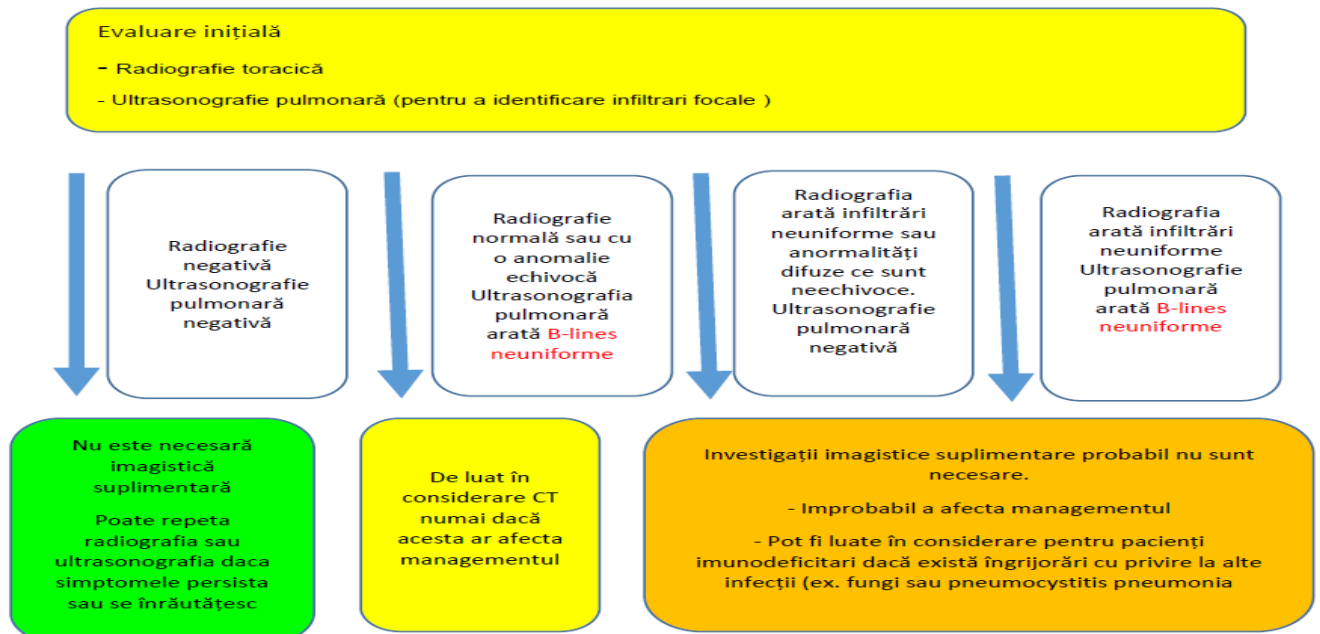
Aloritm de utilizare CT în COVID-19
